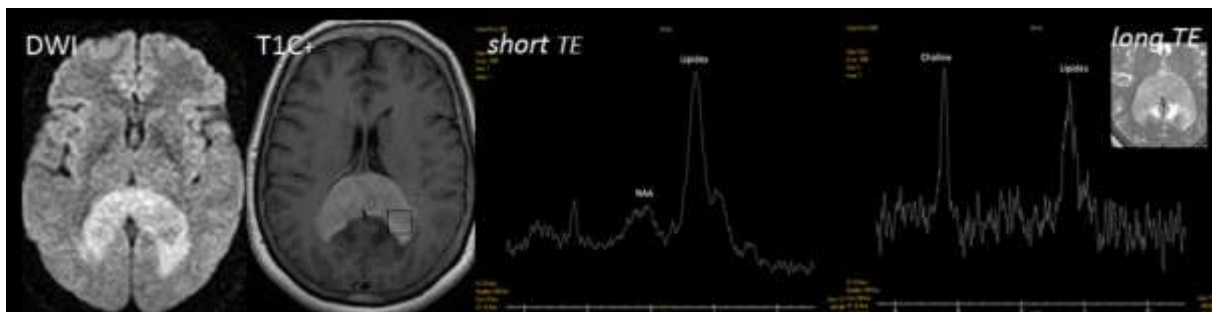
62 years old women with increased intracranial pressure. DWI reveals high signal within the mass of the corpus callosum with homogeneous enhancement on T1C+. MRS (TE 35 ms and 144 ms) show an exaggerated lipid peak, increased choline and decreased NAA: confirmed primary brain lymphoma
